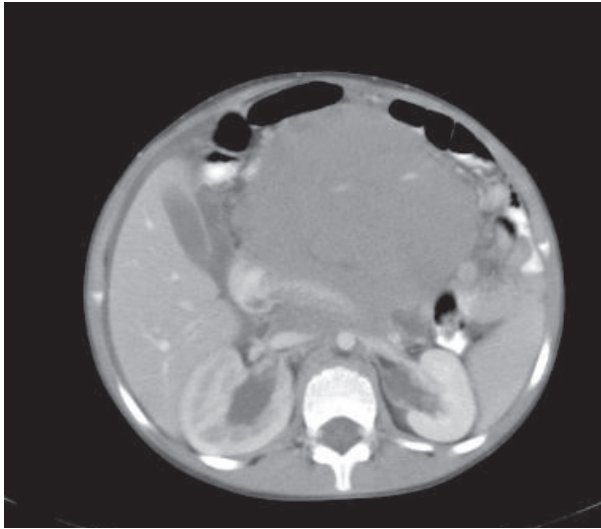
Repeat CT scan at the same level as in Fig. 1.
